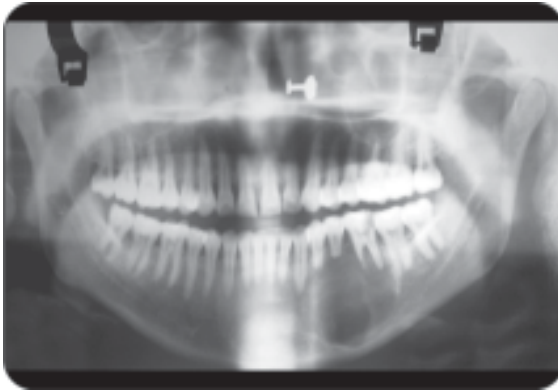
Radiograph of osteosarcoma-I
